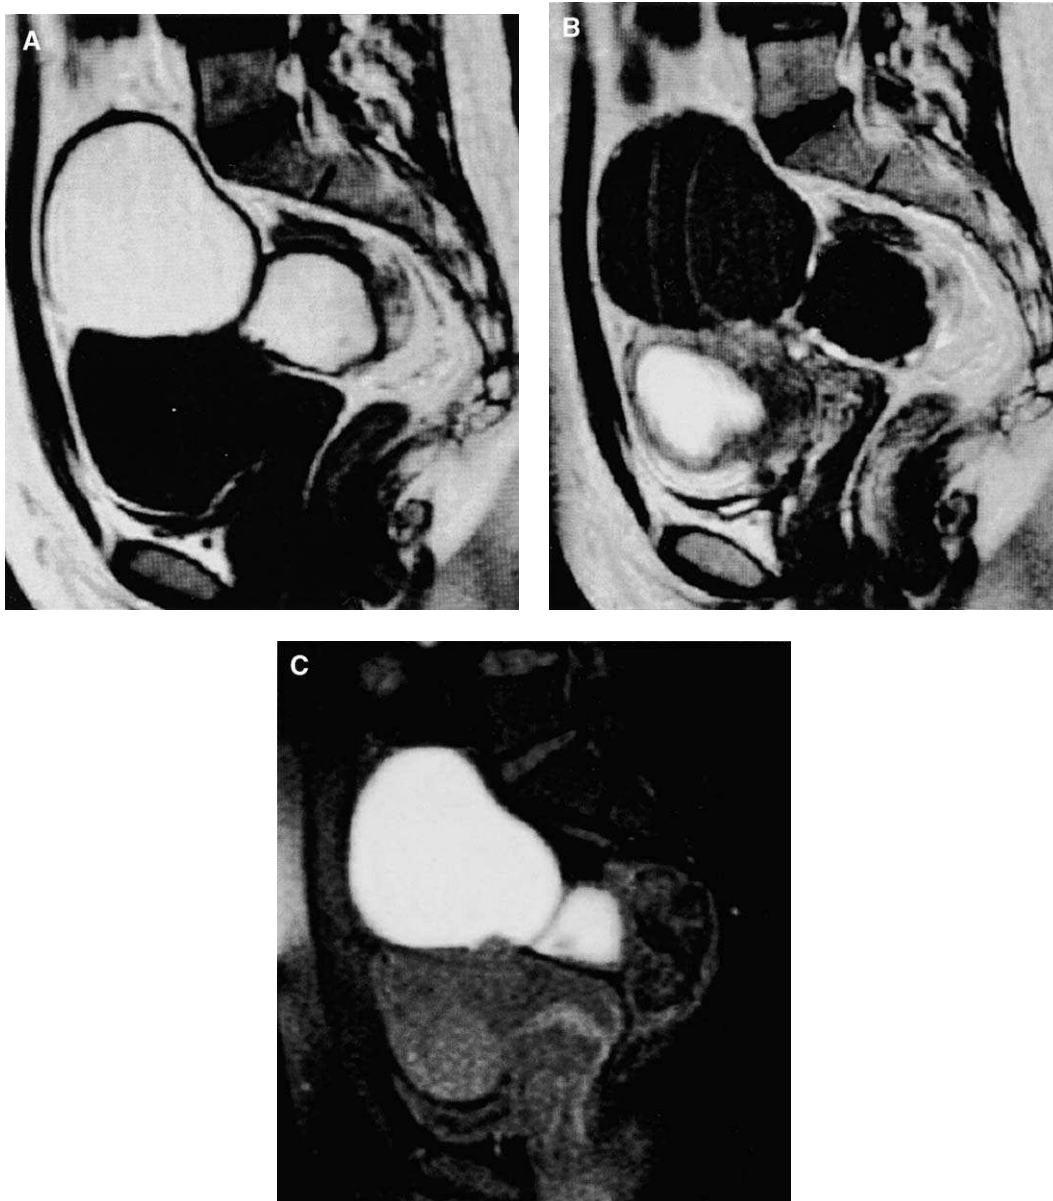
Endometriomas. (A) T1-weighted image shows two cysts of high signal intensity. (B) T2-weighted image shows the cysts to be of heterogeneous low signal intensity. The dorsal cyst shows a lower signal than that of the ventral one. If the lesion exhibits high signal on T1-weighted image and low signal on T2-weighted image, the diagnosis of endometriotic cyst is reliable. (C) Fat suppressed image shows no reduction in signal intensity of the lesion. The diagnosis of an endometrioma is reliable if the lesion consists of multiple high intensity cysts on T1-weighted and fat sat images.
